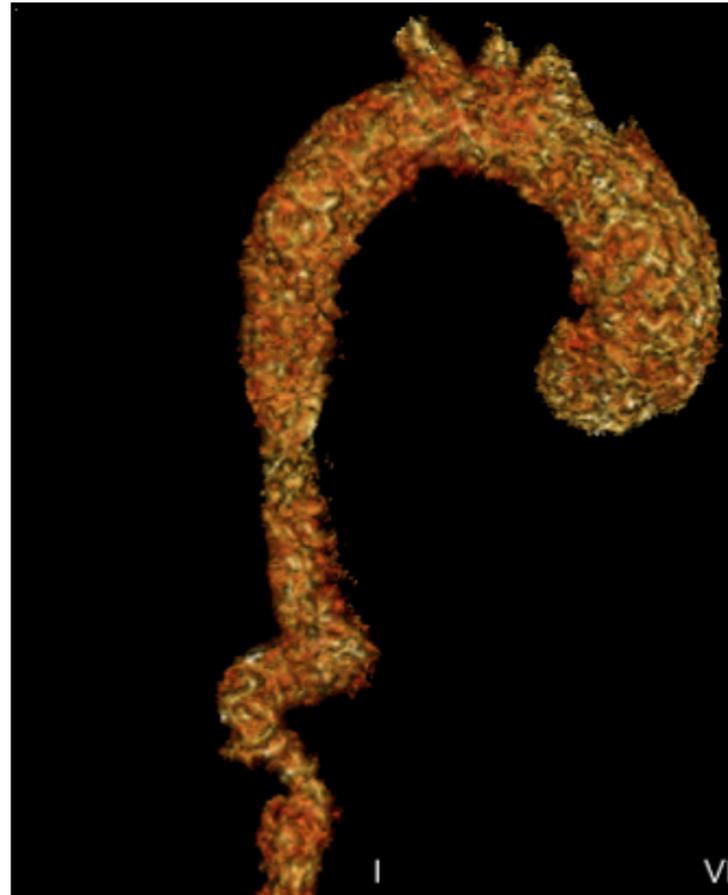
Patient CT angiogram presenting “corkscrew” deformity of descending aorta
